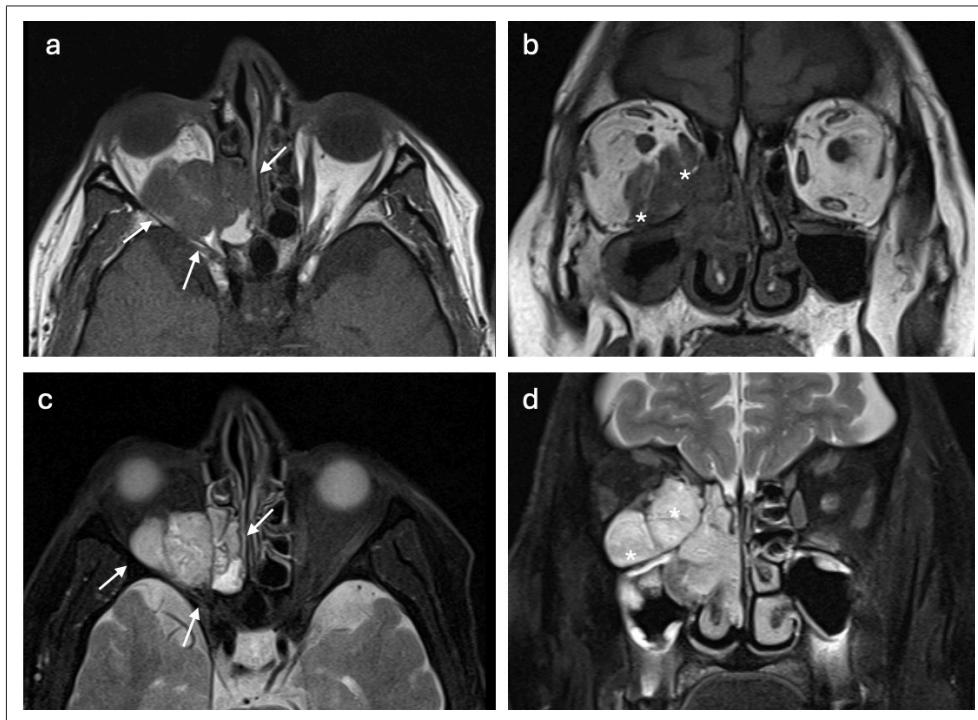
Maxillofacial and orbital MRI sections of the tumour. A homogeneous lesion extending from the retro-orbital area to the orbital apex, ethmoid cells, and nasal cavity was observed (see arrows). There was infiltration in the medial and inferior rectus muscles (see asterisks) and occasionally in the optic nerve: a) T1 axial, b) T1 coronal, c) T2 axial, d) T2 coronal.
